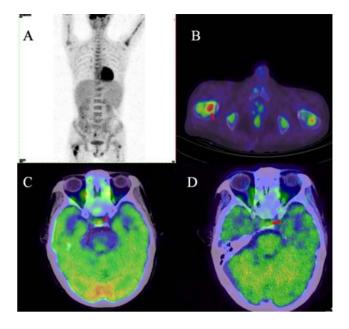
The PET/CT imaging characteristics of ECD in this case. (A) Coronal FDG-PET/CT images showing diffuse elevated metabolic activity in the long bones of limbs. (B) Axial ¹⁸FDG-PET/CT fusion images in lower limbs showing osteolytic lesion in the right femur (arrow) and the standard uptake value max (SUVmax) was 5.8. (C) Axial ¹⁸FDG-PET/CT fusion images in pituitary gland showing elevated metabolic activity in posterior pituitary (arrow) and the SUVmax was 5.6. (D) Axial ¹³N-NH₃-PET/CT fusion images in pituitary gland showing descending metabolic activity in posterior pituitary (arrow).
